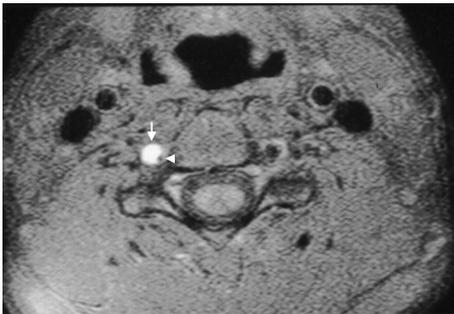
Magnetic resonance imaging. Mural hematoma (arrow) of the left vertebral artery with an eccentric narrowed lumen (arrowhead).
